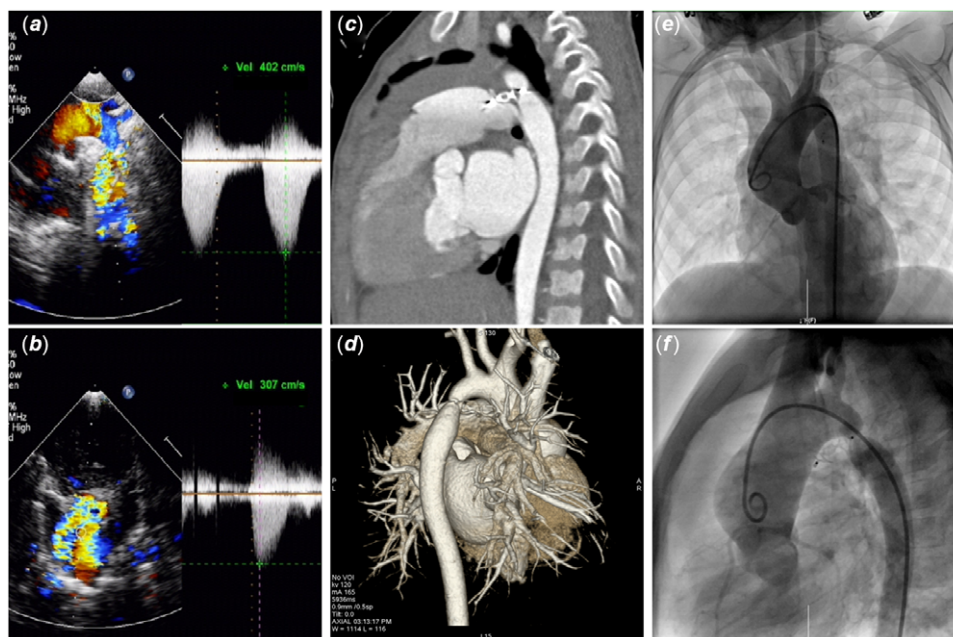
Images in follow-up. Echocardiography showed 4 m/s flow acceleration in descending aorta (A) and aortic valve regurgitation (B). Sagittal view (C) and three-dimensional reconstruction (D) of CT angiography. Antero- (E) and lateral-posterior (F) aortography.
